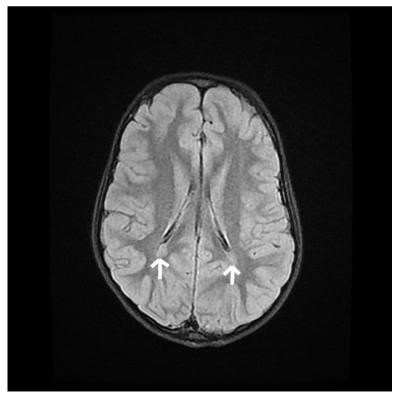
MRI Brain section revealing bilateral periventricular nodular heterotopia.
